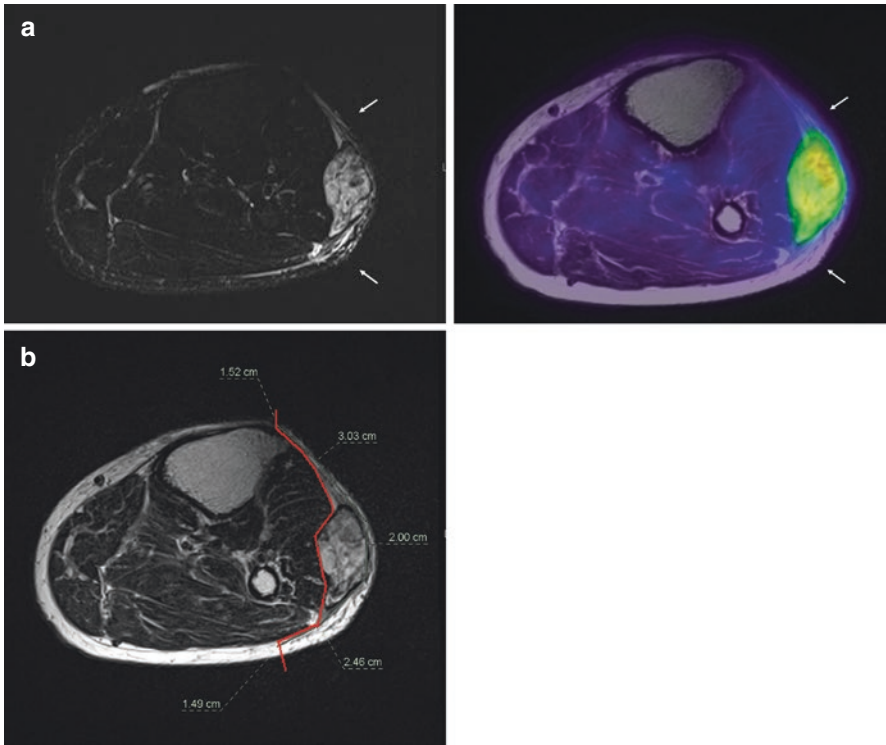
Myxofibrosarcoma of the left calf. (a) MRI showing the tail sign, which is the reaction layer extending along the fascia in the subcutaneous tissue. PET/MRI showing unclear F-18 FDG accumulation in the reaction layer. (b) Presurgical planning was based on PET/MRI findings, but tumor invasion assessment was too optimistic in this case
